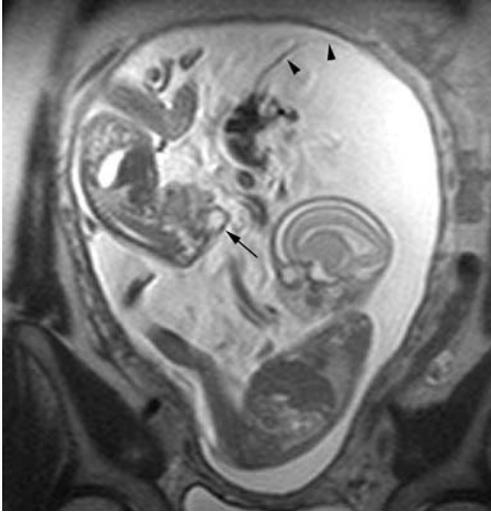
Discordant growth of diamniotic dichorionic twins at 23 weeks gestational age. Axial T<sub>2</sub>-weighted images of the uterus show twin A being smaller than twin B. Note that although the membrane appears relatively thin (arrows), sonograms earlier in gestation (not shown) had proved these to be dichorionic twins. Note also the relatively large amount of amniotic fluid around twin B indicating mild polyhydramnios.
